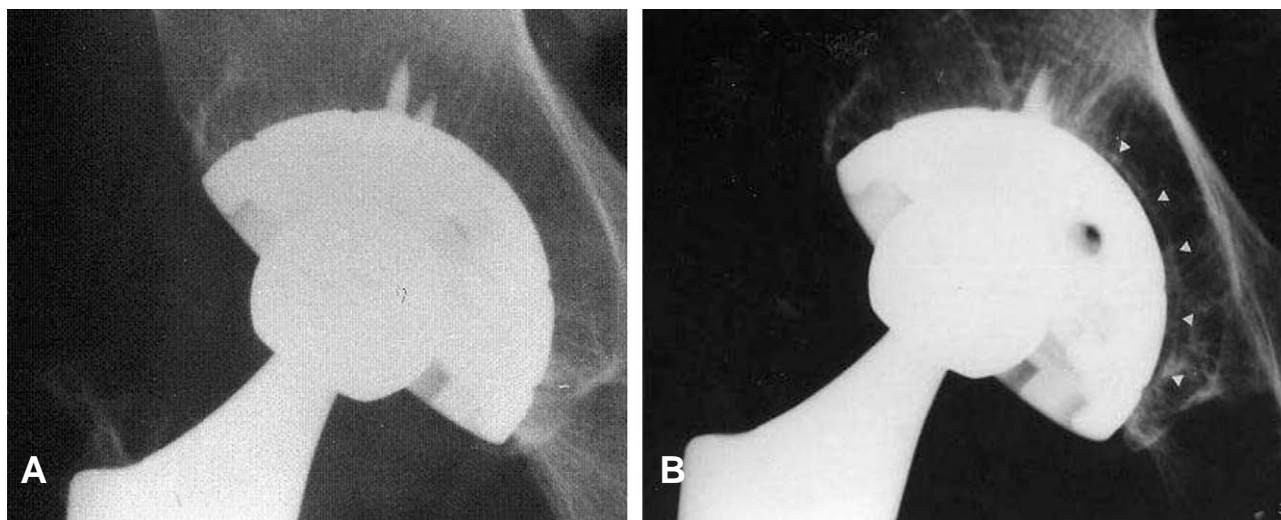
(A) Radiograph at 2 years after total hip arthroplasty for osteonecrosis of the femoral head shows a well osteointegrated cup. (B) At 10 years after surgery, the cup is revised for loosening.
